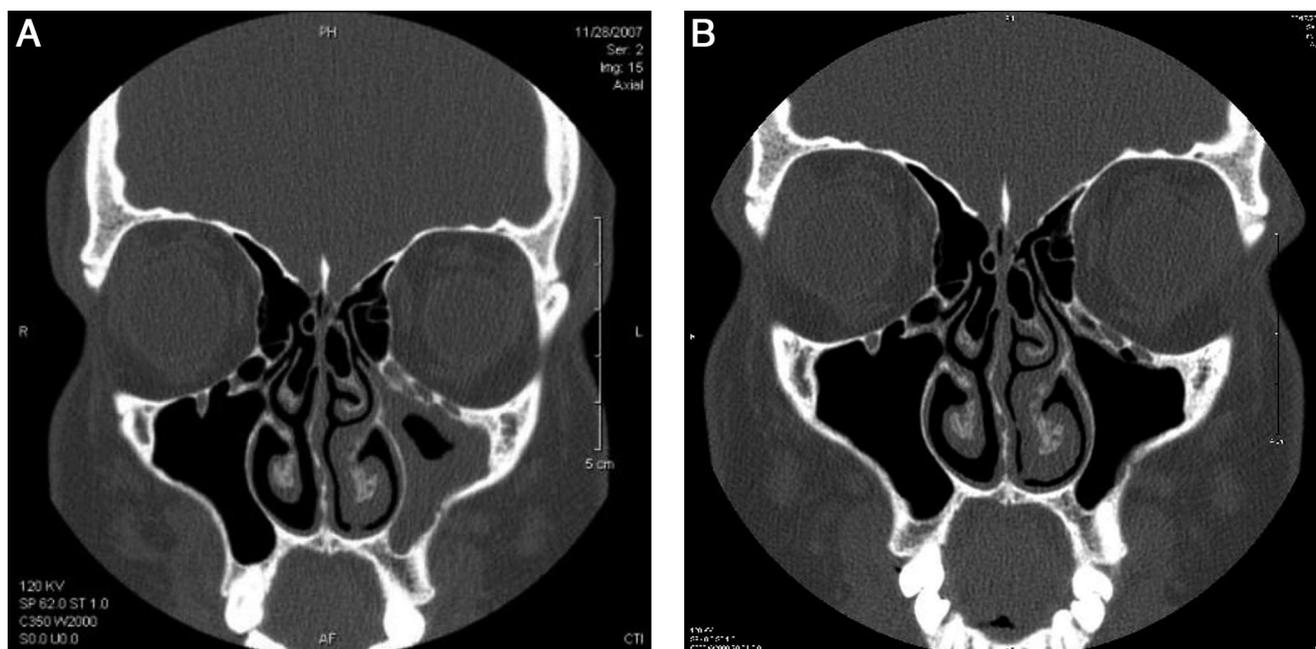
(A) Preprocedure coronal computed tomography (CT). (B) Three-month postprocedure coronal CT.
